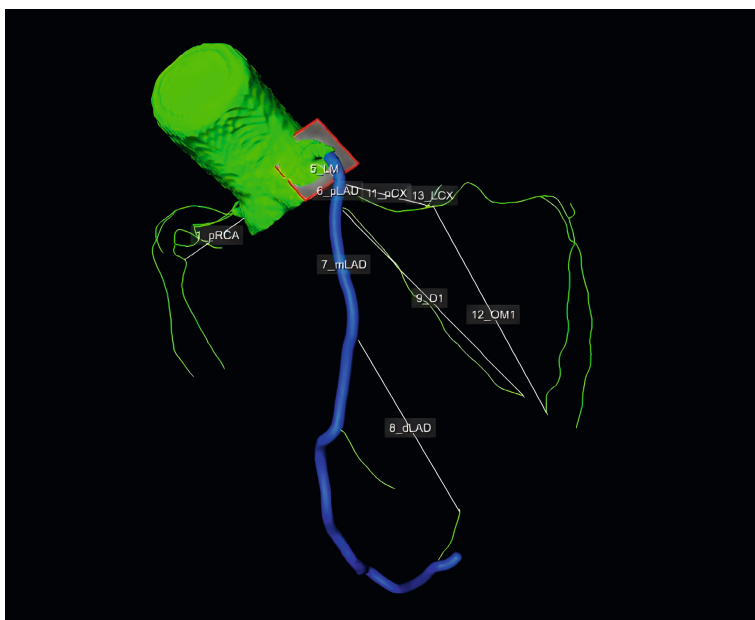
The complete coronary tree is extracted from the CCTA. In this example, the left anterior descending artery (LAD) is marked in blue for performing plaque delineation. LM left main artery, pLAD proximal left anterior descending artery, dLAD distal left anterior descending artery, pRCA proximal right coronary artery, pCX proximal circumflex artery, LCX left circumflex artery, D1 first diagonal artery, OM1 first obtuse marginal artery, mLAD mid left anterior descending artery, CCTA coronary computed tomography angiography
